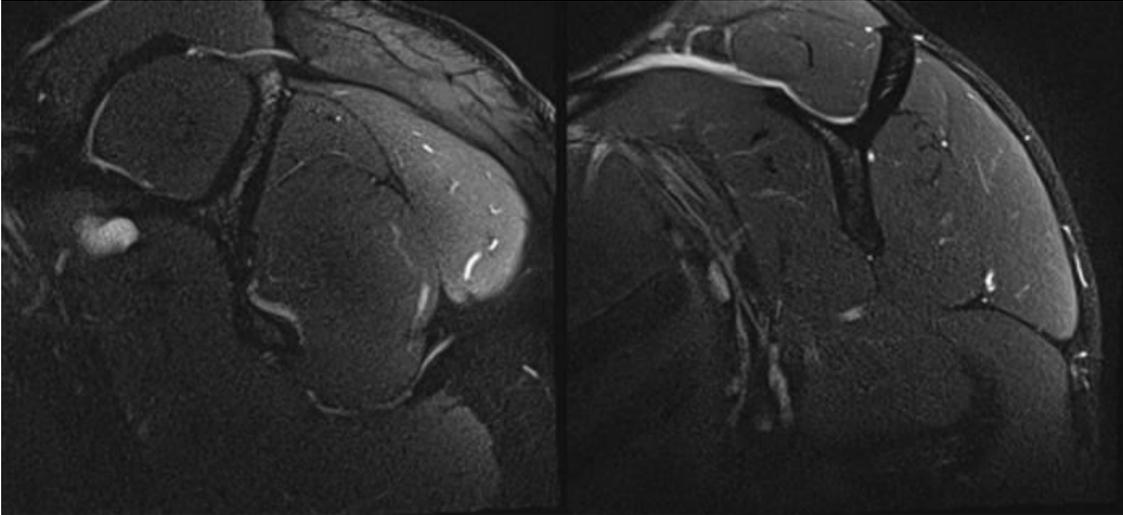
T2-weighted fat-suppressed image at the level of the supraspinatus fossa. Note the bulky rotator cuff muscles bellies from muscle hypertrophy. The supraspinatus muscle belly bulges beyond the confines of the supraspinous fossa.
